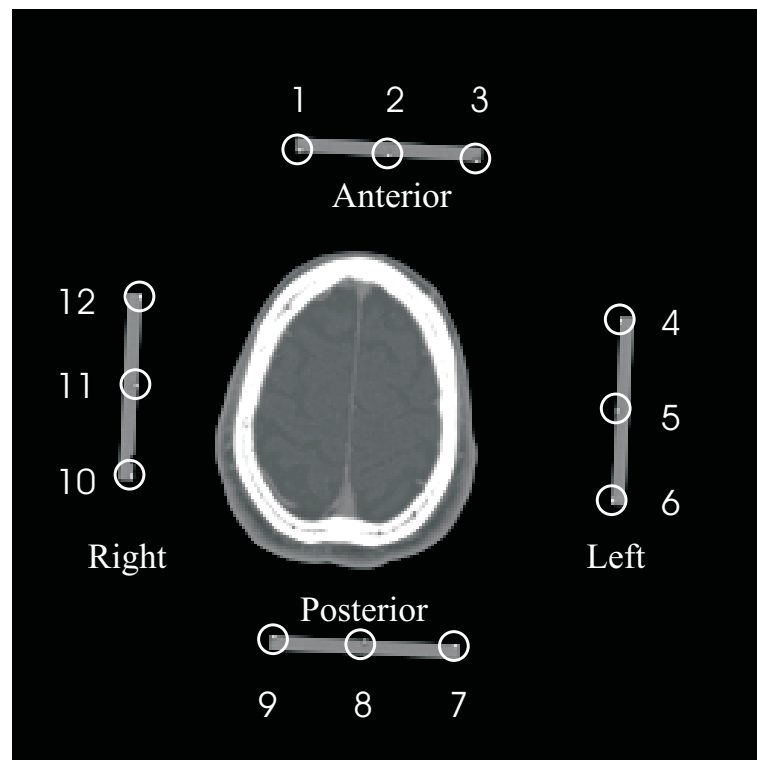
Fiducial points in a CT-image.
